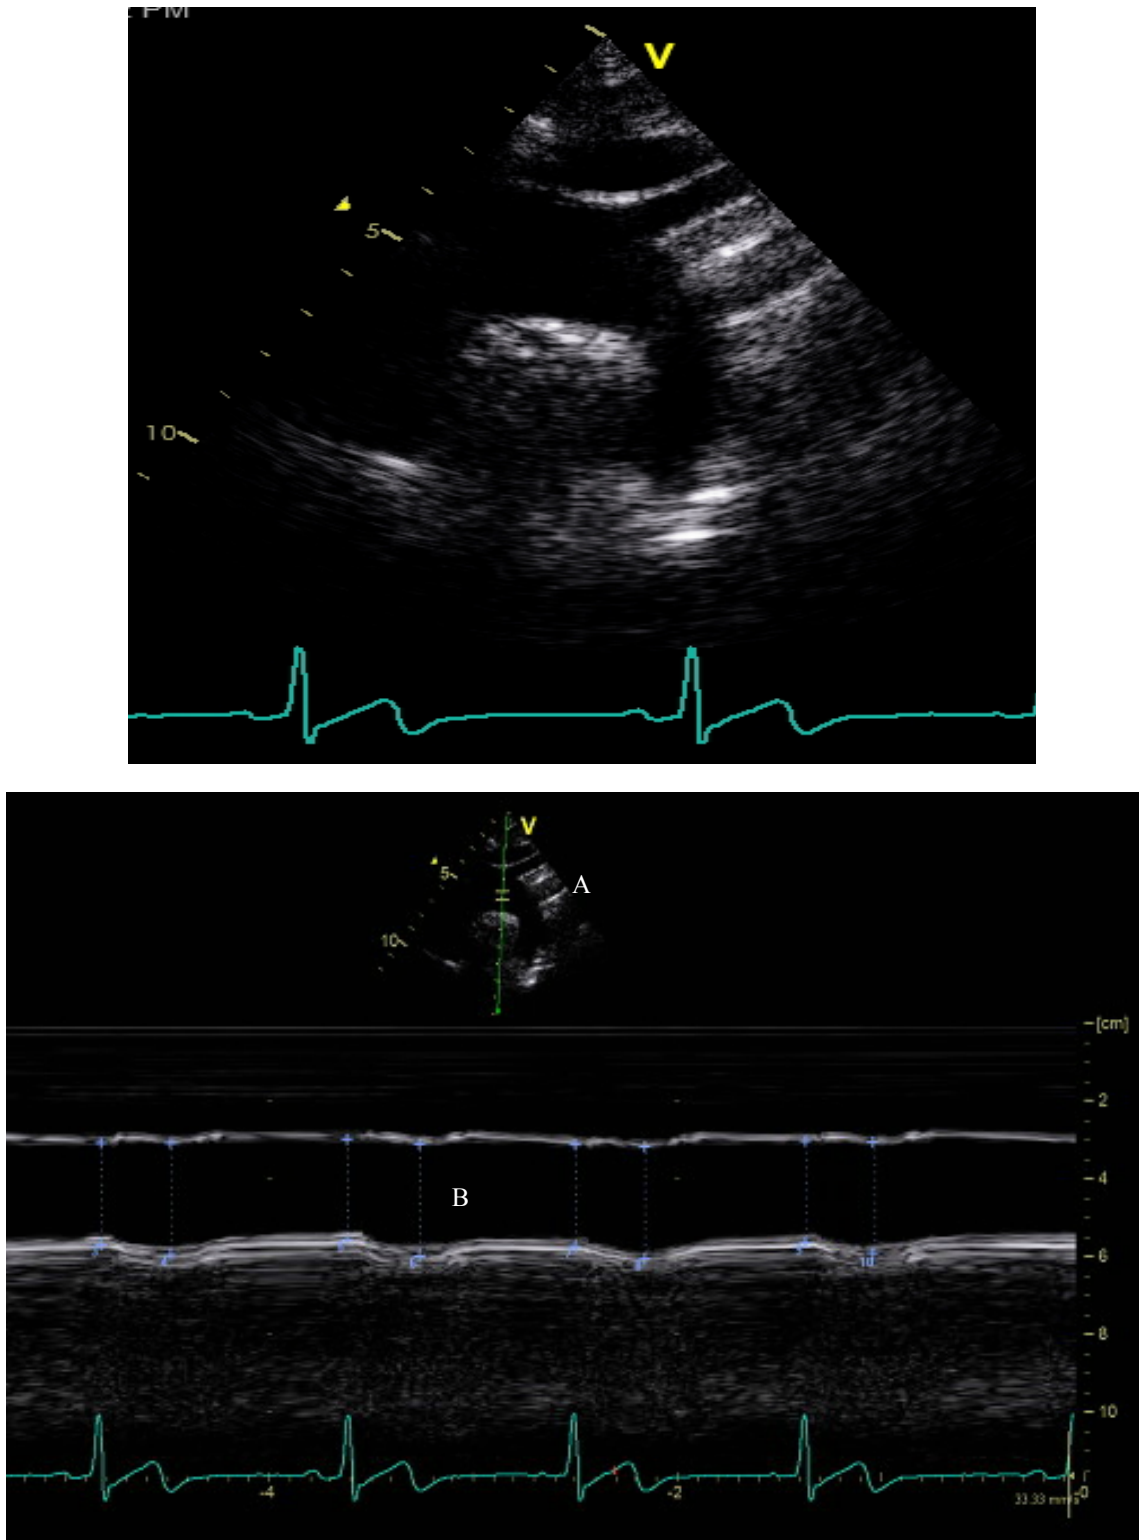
Figure B-3. Longitudinal view of the AA (aortic arch) using B-mode (top) and M-mode (bottom) ultrasonography. Note: the M-line (A) was positioned between the brachiocephalic and left CCA (common carotid artery) branches. Diameter measurements were taken in M-mode over time using EchoPAC calipers (B).
